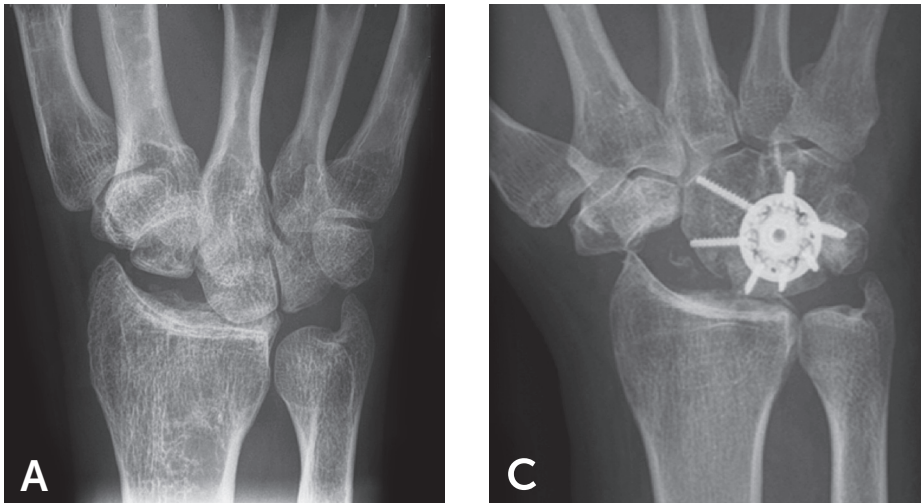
Plain radiographs (A/P view) of proximal row carpectomy (PRC) (A) and four-corner fusion (4CF) (B).
